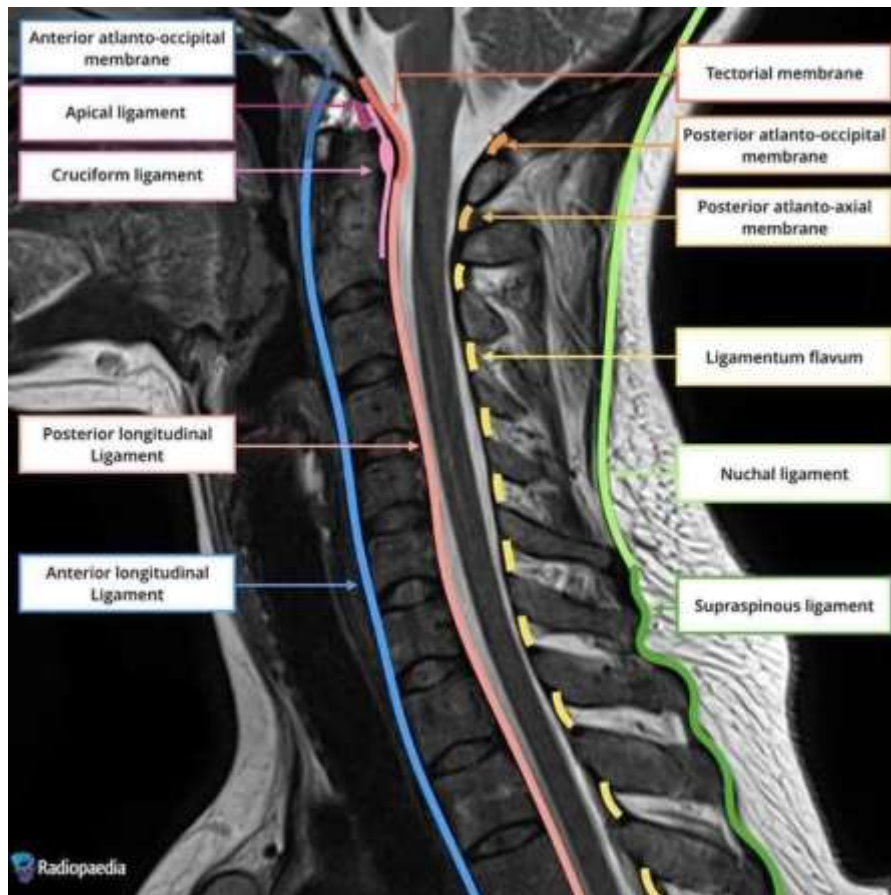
Normal Magnetic Resonance Imaging of the cervical spine showing the various ligaments
